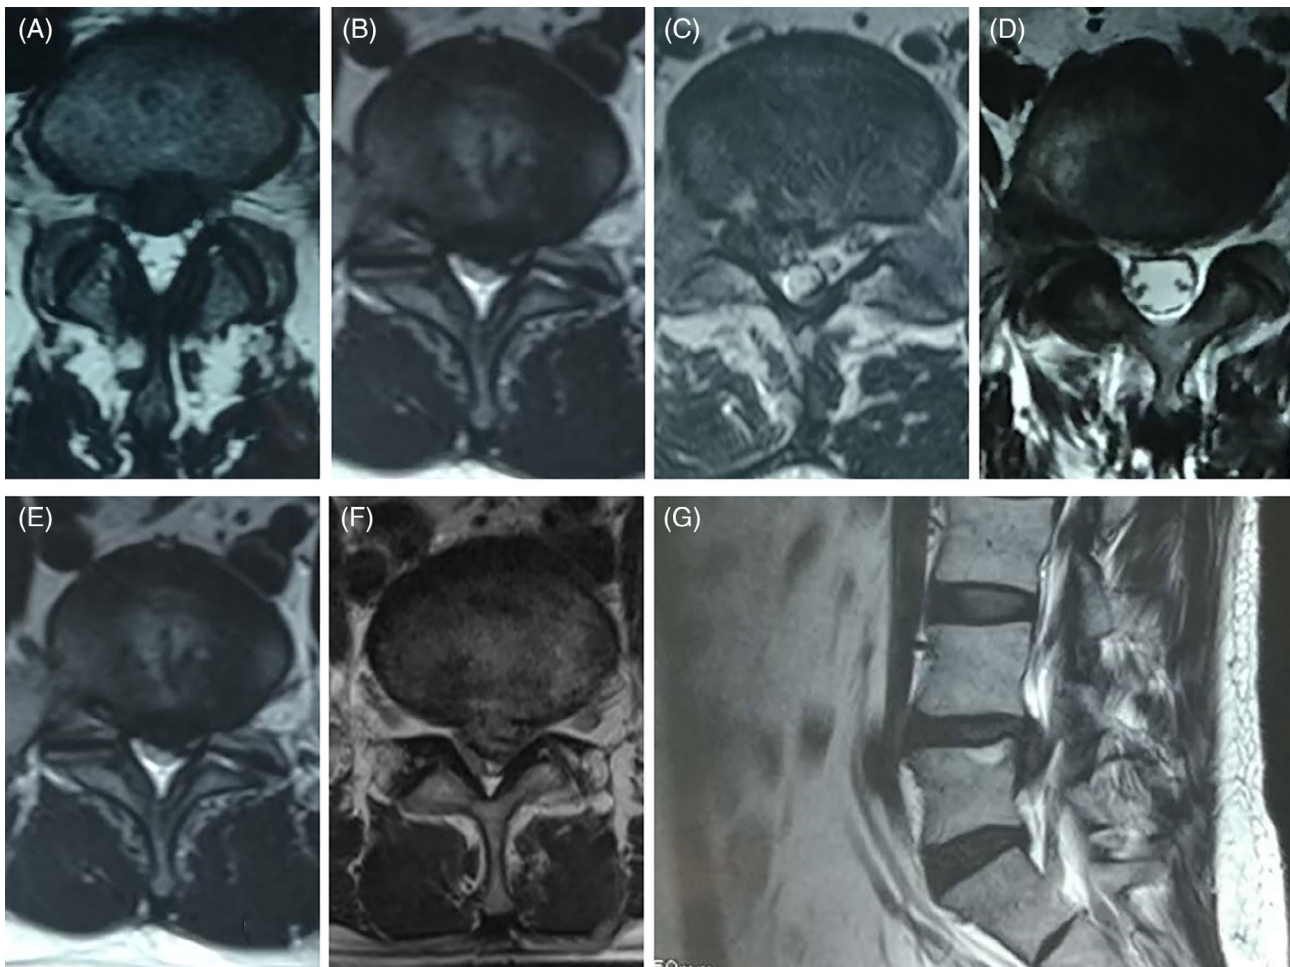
Preoperative magnetic resonance imaging scans. (A) central herniation. (B) paramedian herniation. (C) foraminal herniation. (D) extraforaminal herniation. (E) protrusion. (F) extrusion. (G) migrated herniation.
